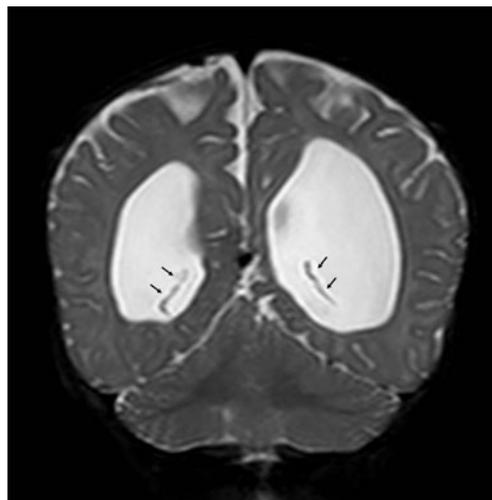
Magnetic resonance imaging (T2-weighted, coronal view) of a pediatric patient with significant hydrocephalus. *Arrows* indicating the choroid plexus in the lateral ventricles
